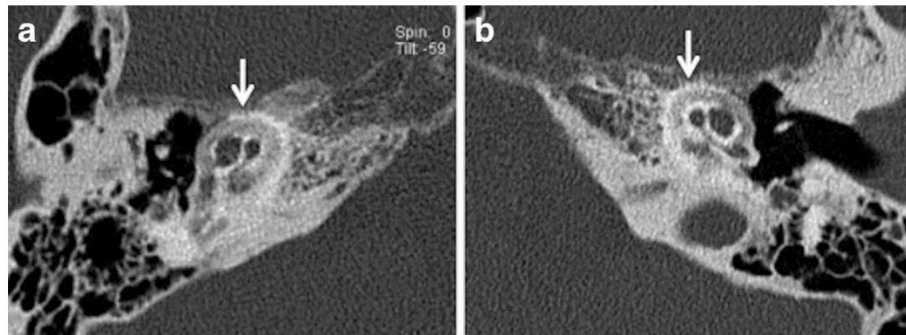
Axial computed tomography scan of the petrous bone in patients with otosclerosis. (A) Grade 1: solely fenestral involvement, otospongiotic lesion on the anterior border of the vestibulum (white arrow). (B) Grade 2A: double ring effect (black arrow). (C) Grade 3: diffuse confluent cochlear involvement with an unrecognizable cochlea.
